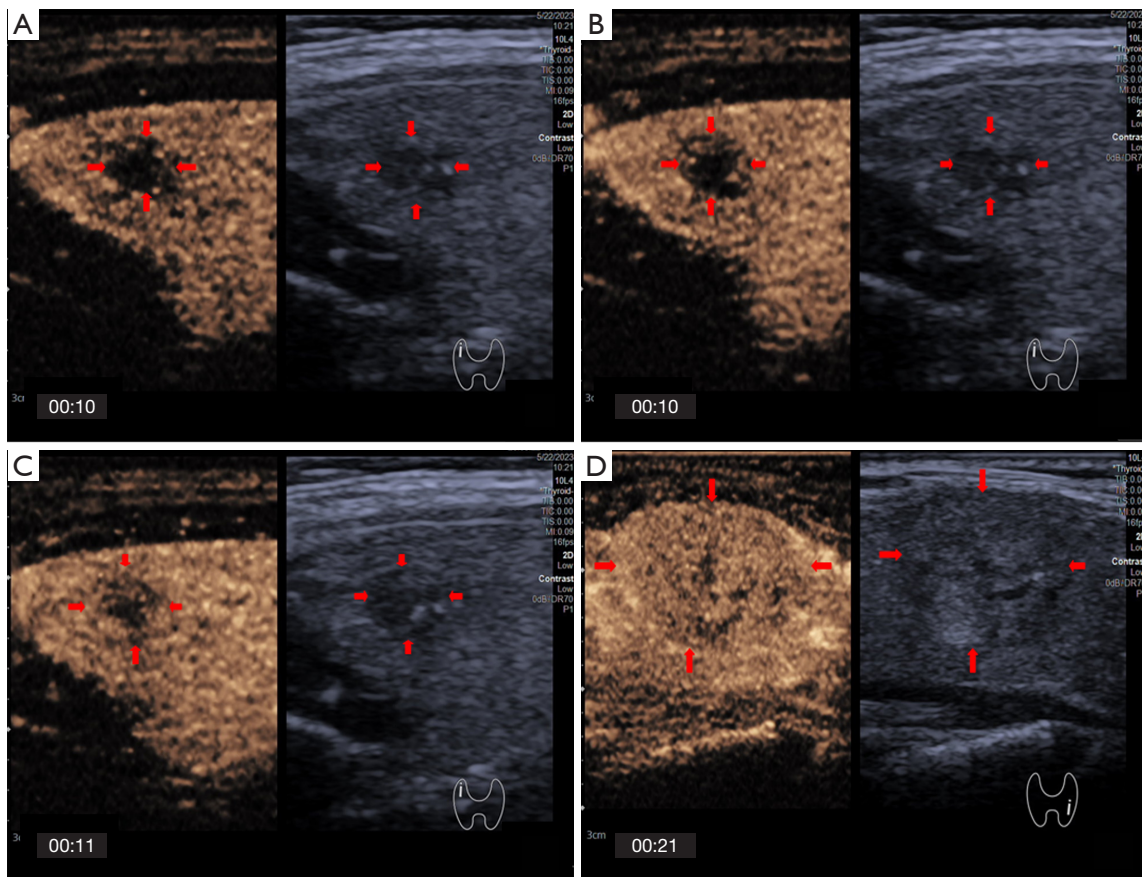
Enhancement direction on CEUS. (A–C) Images showing centripetal enhancement of the same PTC nodule (red arrows) in the right lobe of thyroid gland of a 69-year-old woman. (D) Image of a case of a benign nodule (red arrows) in the left lobe of thyroid gland of a 41-year-old woman showing a feature of scattered enhancement on CEUS. The minutes and seconds after the contrast media injection are indicated by numbers in the bottom left corner of each panel. CEUS, contrast-enhanced ultrasound; PTC, papillary thyroid carcinoma.
